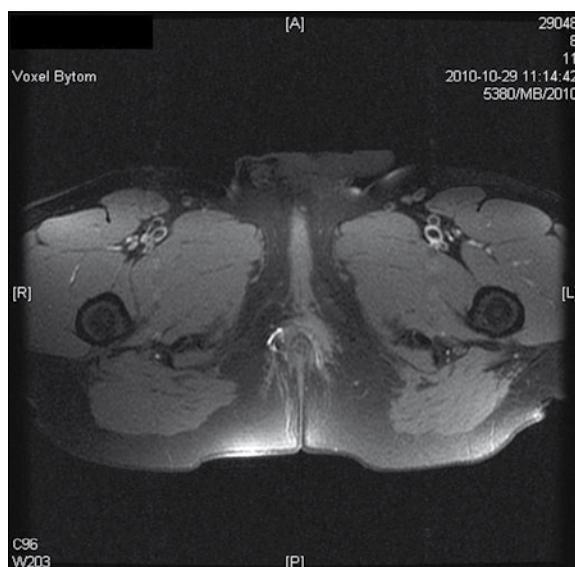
MR examination, transverse T1-weighted images with fat saturation. Horseshoe fistula; fistulous canal filled with contrast agent.
